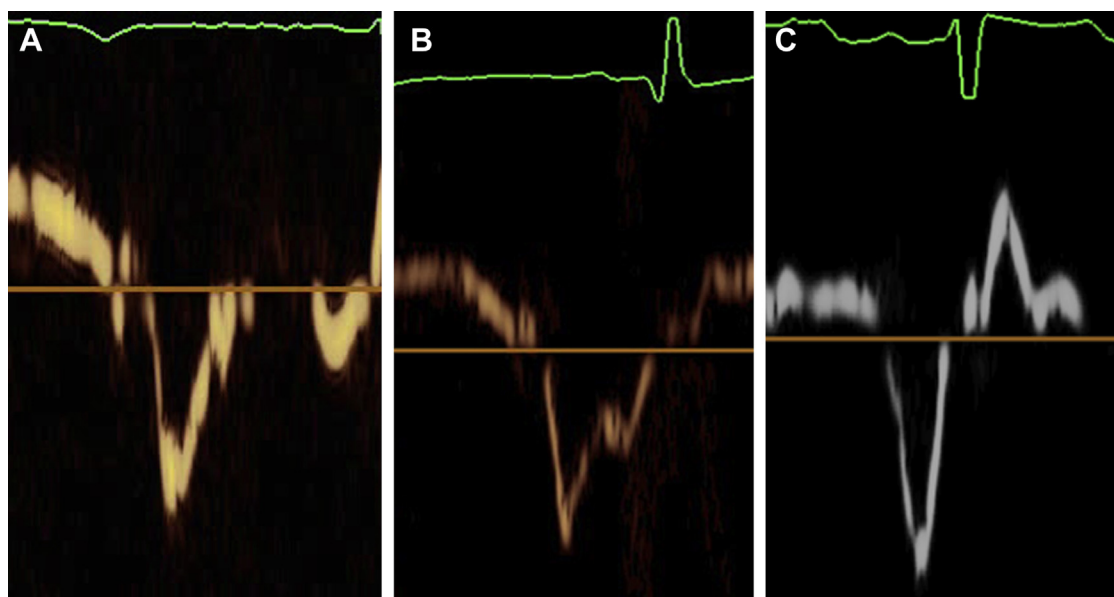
Doppler tissue imaging at the atrioventricular annulus E' and A' fusion: (A) nonfused E' and A' waves; (B) partial fusion of E' and A' waves; (C) complete fusion of E' and A' waves.
